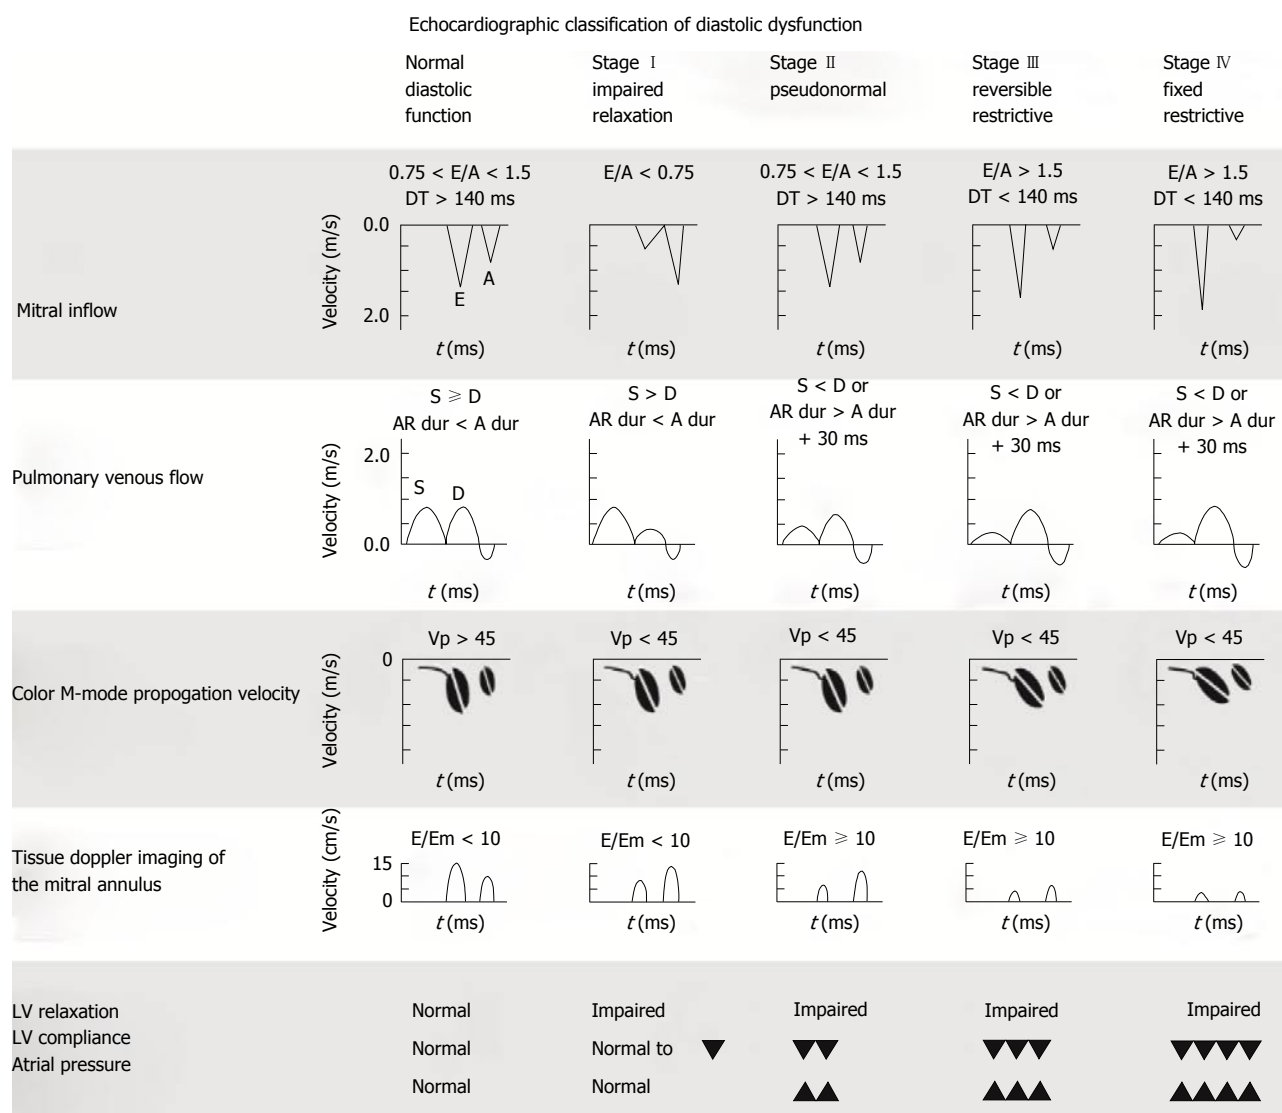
Diastolic function classification. Echocardiographic classification of diastolic dysfunction adapted for transesophageal echocardiography is shown. A: Peak late diastolic transmitral flow velocity; A dur: Duration of mitral inflow A-wave; AR dur: Peak pulmonary venous atrial reversal flow velocity duration; D: Peak diastolic pulmonary venous flow velocity; DT: Deceleration time; E: Peak early diastolic transmitral flow velocity; Em: Peak early diastolic myocardial velocity; LV: Left ventricle; S: Peak systolic pulmonary venous flow velocity; Vp: Flow propagation velocity. With permission of Informa Healthcare adapt from reference^[36].
